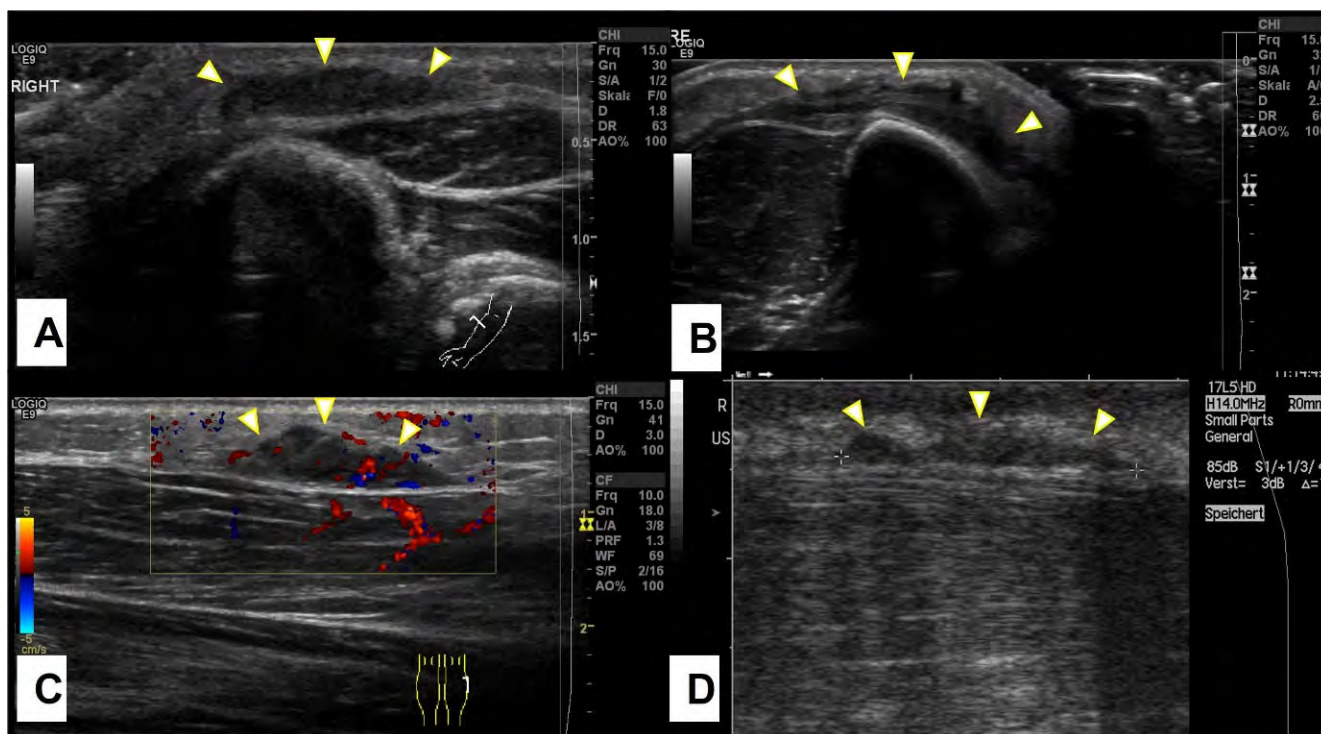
Representative slices of ultrasound imaging of subcutaneous granuloma annulare (SGA). The lesions are strictly epifascial with hypo- and hyper-echoic zones and mild hypervascularization. A common finding is the cap shape of these lesions, marked with arrowheads. The depicted lesions were located on (A) the right forearm; (B) the right lower leg; (C) the left lower leg; (D) the right lower leg.
